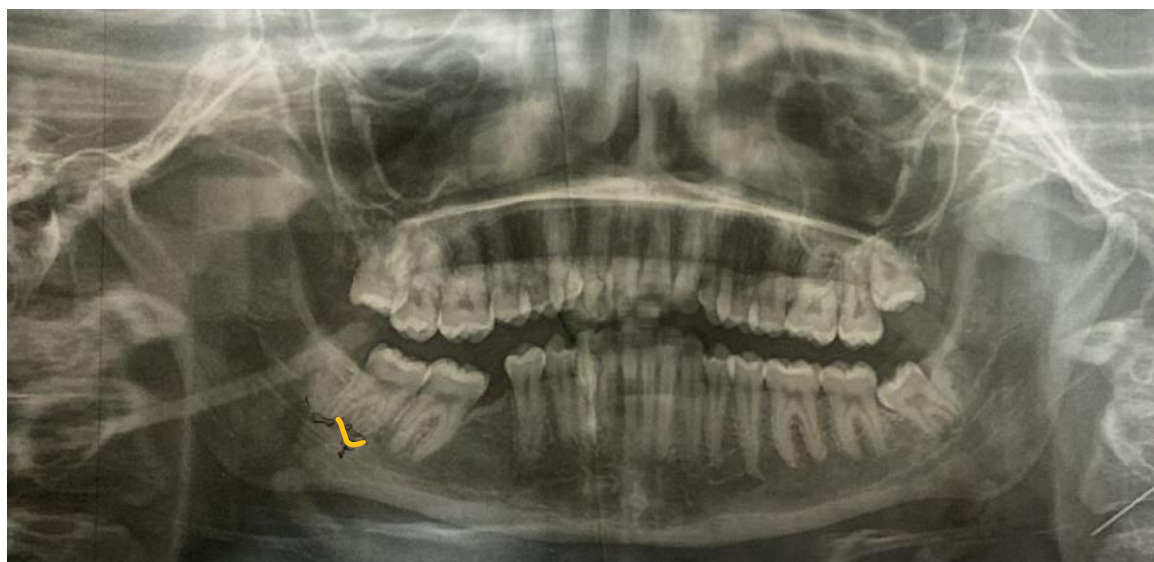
Small periapical pathology related to mandibular second left molar
